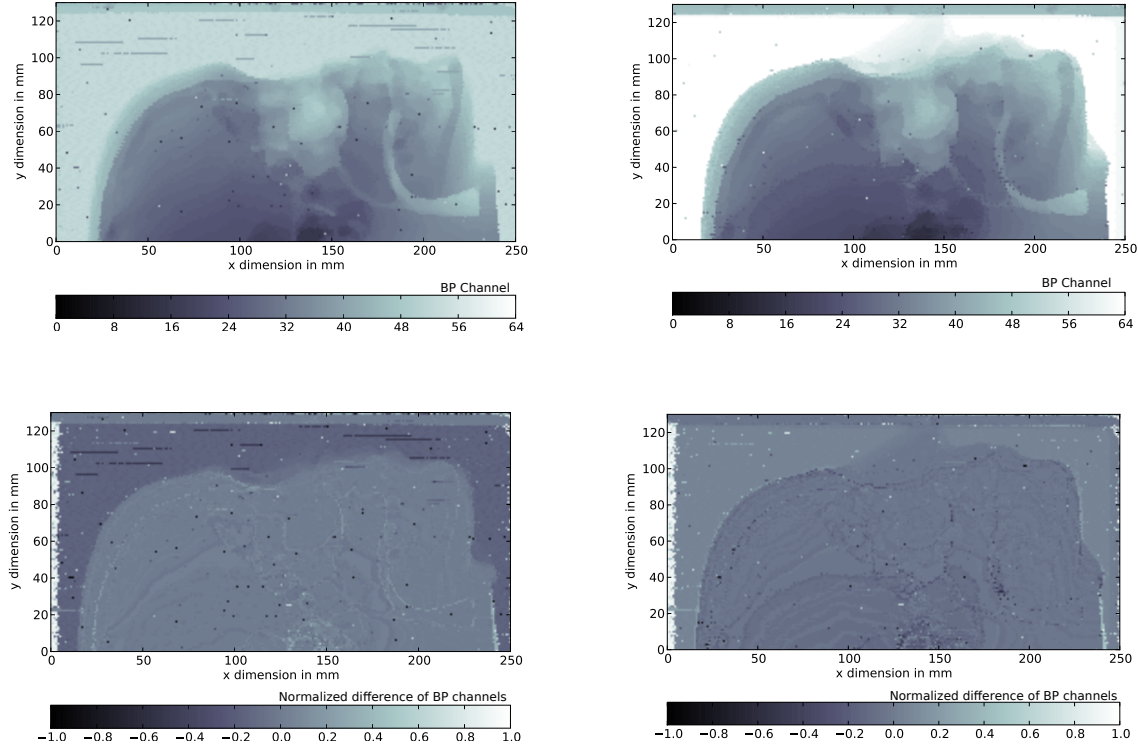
The top panels show images, converted to a common reference thickness of 45 mm PMMA absorber, of two different radiographies obtained at fixed carbon ion beam energy of 375.32 MeV/u, 3.5 mm FWHM spot size and with different PMMA thickness (20 mm, left, and 80 mm, right) in front of the ICs stack. The lower panels show images of the difference of the two radiographies above obtained by subtracting each of them from a reference image obtained with 45 mm absorber and normalizing them by the mean value.
